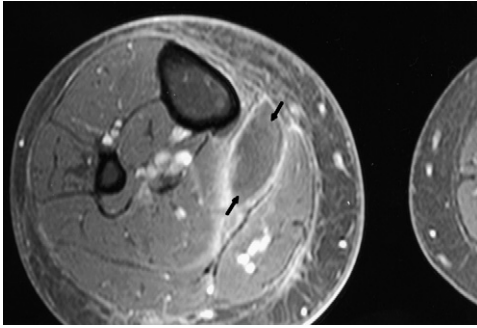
Plantaris tear. Axial postcontrast fat-suppressed T1-weighted image demonstrates a peripherally enhancing hematoma (arrows) between the soleus and gastrocnemius.
